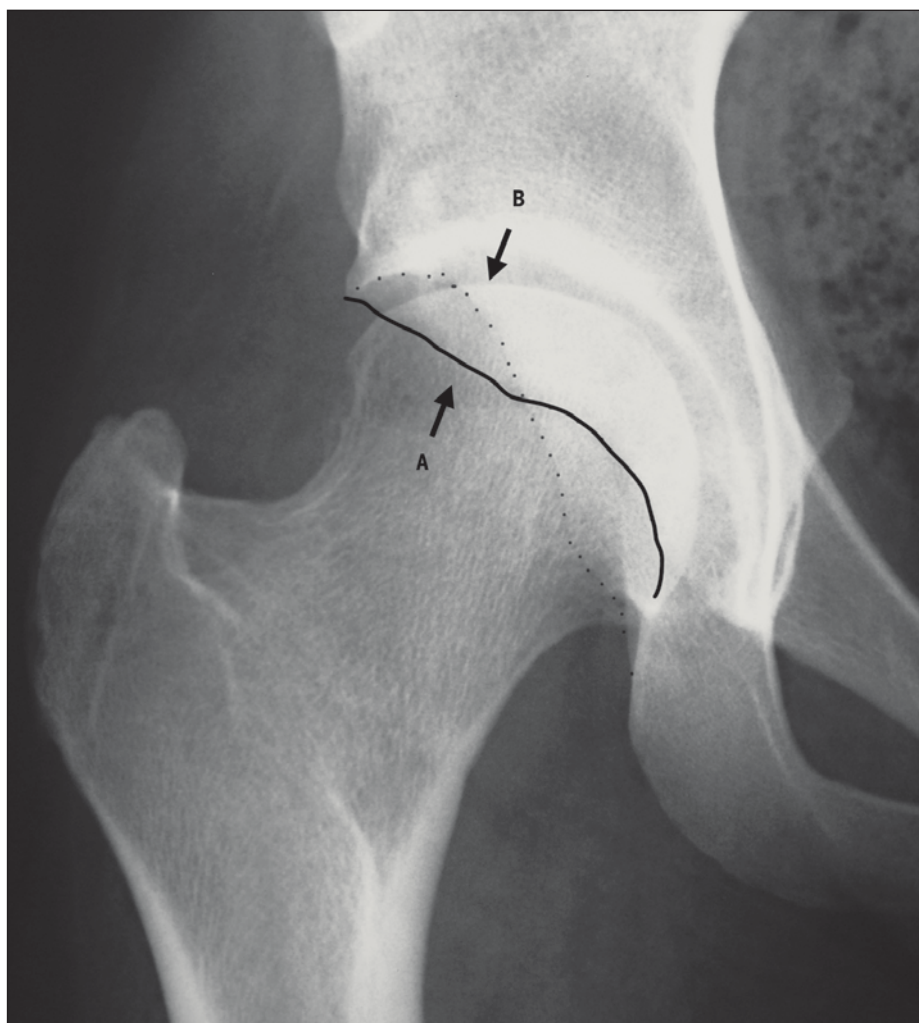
Acetabular retroversion is described qualitatively on an anterior-posterior radiograph by identifying the crossover sign, in which the anterior border of the acetabular rim (A) extends laterally compared to the posterior border (B).
